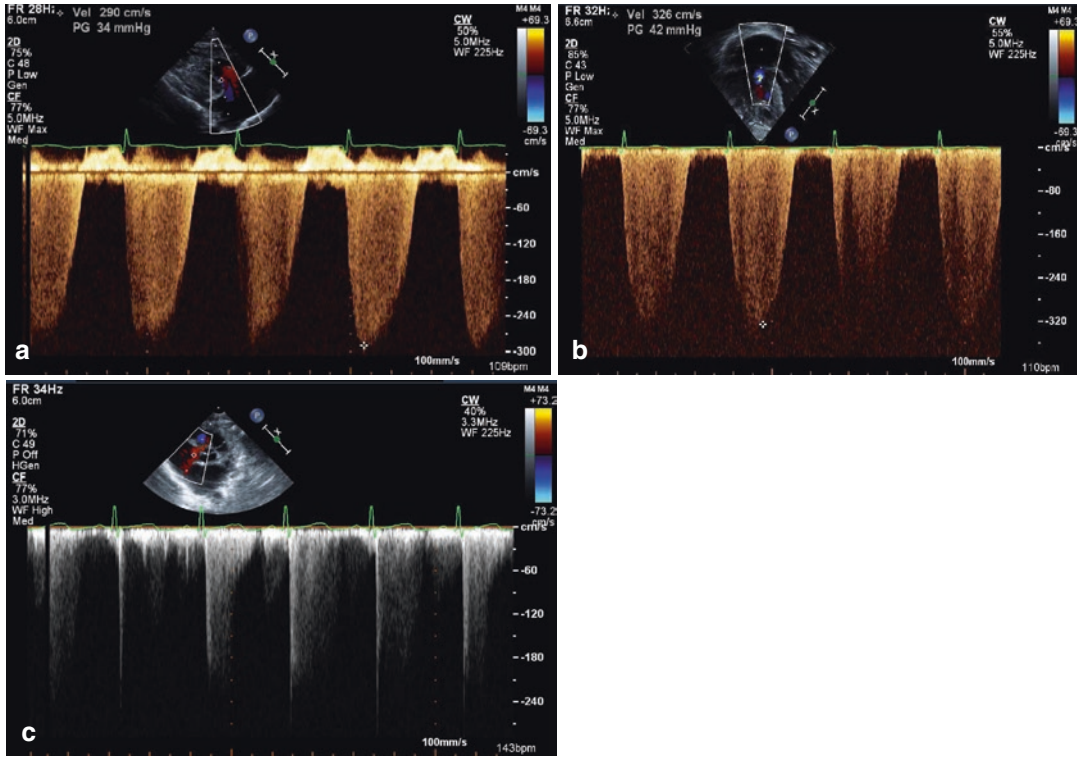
Tricuspid regurgitation jet velocity, (a) Parasternal long axis right heart view with full envelope; (b) Apical 4-chamber view with full envelope; (c) Parasternal short
